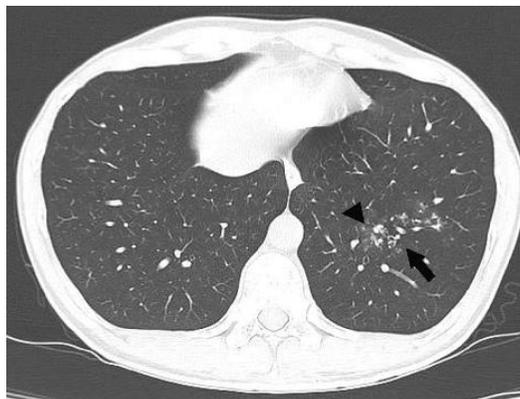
A case of COVID-19 pneumonia confirmed by RT-PCR. 38-year-old man, day 5 after symptom onset, with moderate severity criteria. Axial chest CT shows bilateral peripheral and central ground glass opacities (arrows) with microvascular dilatation (arrowheads). Time to conversion: 13 days.
